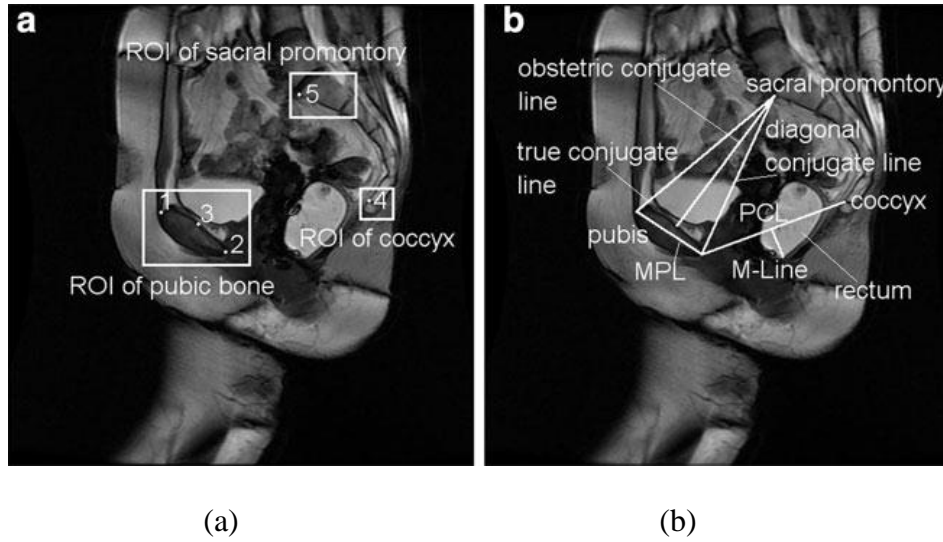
Region of interests and proposed MRI-based features. (a) Regions of interest, (b) Current and proposed MRI-based features
